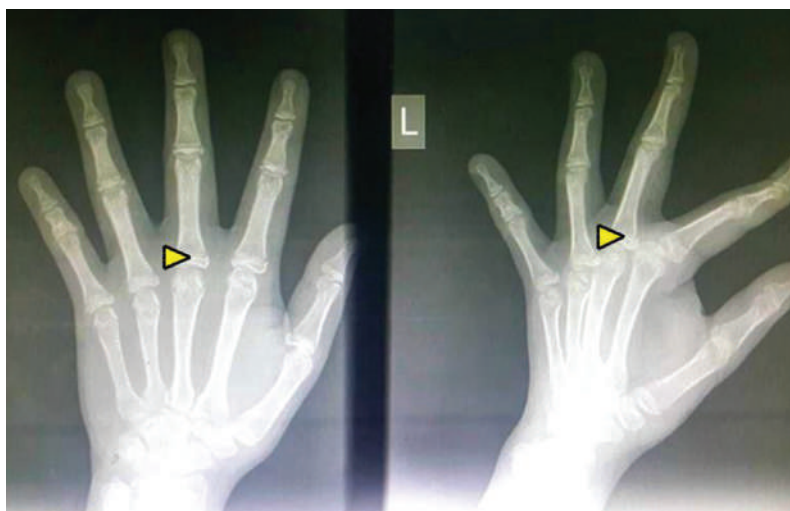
Radiograph of the left wrist revealed non-fusion of epiphyseal plates (yellow arrowheads) with bone aging for female of 13 years old by Greulich and Pyle standards.
